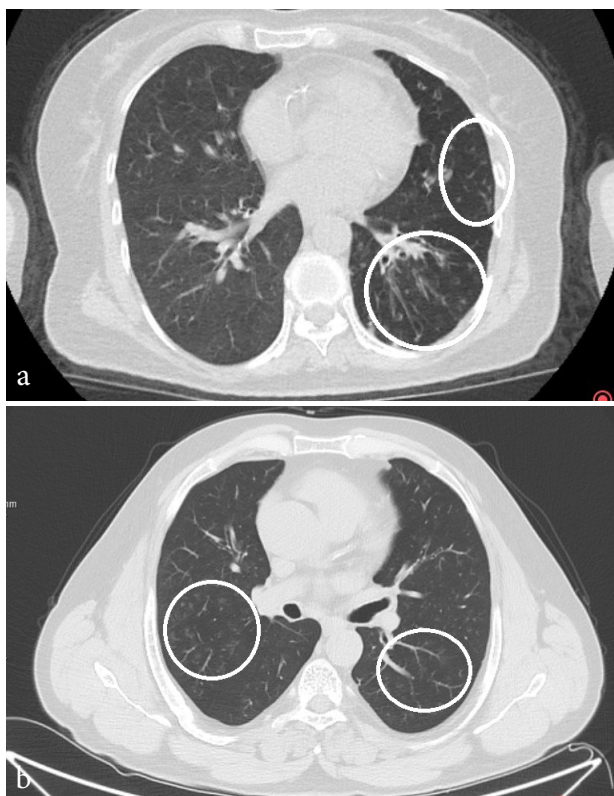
45 year-old woman with suspected COVID-19 infection and PCR (-) test result. Axial CT scans (a,b) indicated a focal ground-glass opacities and tree-in-bud sign in lingual segment of the left lung (a) and left lower lobe (b) (white circles). The CT imaging score was evaluated as score 2 (atypical features for COVID-19).
